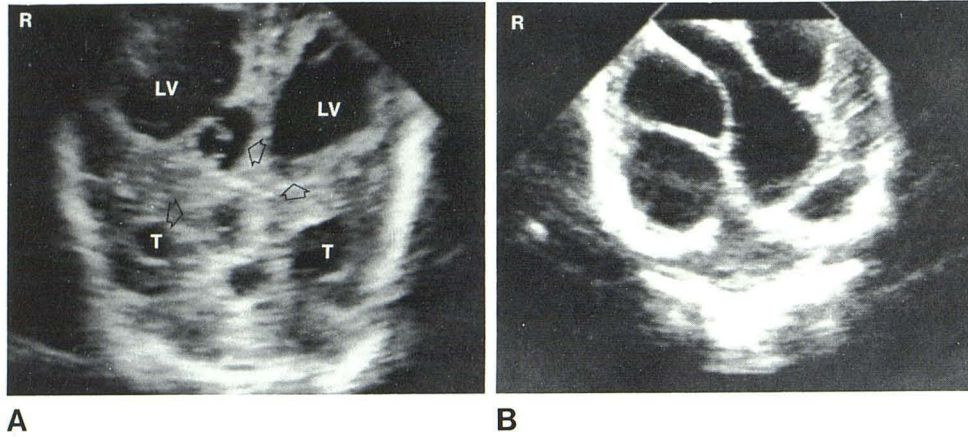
Case 1. Coronal sonograms. A, Dilated irregular lateral ventricles with smaller cavities (*arrows*) in surrounding brain. LV = body of lateral ventricle; T = temporal horn of lateral ventricle. B, 6 months later. Almost complete replacement of brain by cysts. Remaining strands of brain undulate loosely in cyst fluid. Ventricles no longer discernible.
